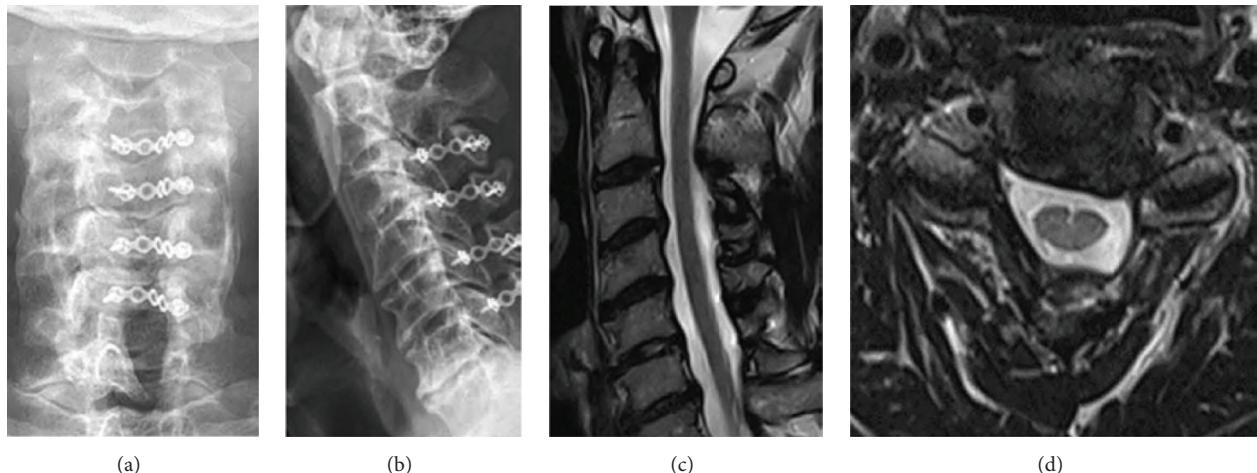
Postoperative X-ray at 4 years demonstrated well cervical curvature with C6-C7 disc space narrowing at anterior to posterior (a) and lateral (b) views. Post-op MRI revealed patent spinal cord without compression at sagittal plane (c) and axial plane (d).
